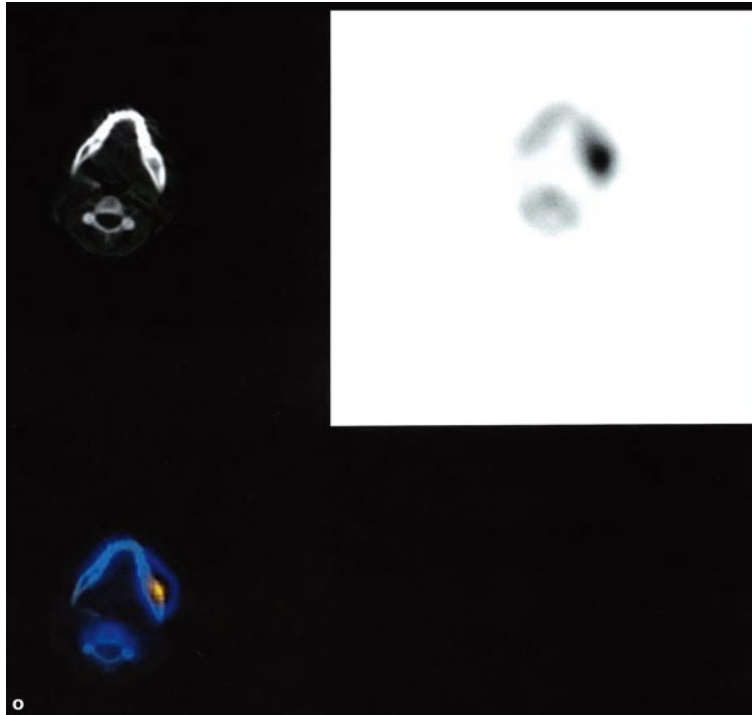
ze (continued) Skeletal scintigraphy of the patient at initial presentation (I) demonstrates a significant uptake of radioactive tracer in the left mandible (hot spot); other (extragnathic) lesions are not identified. m-ze see next page
